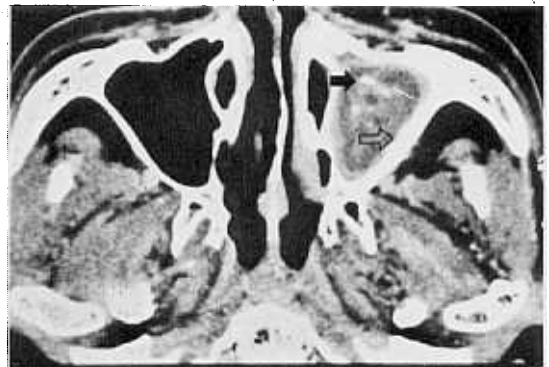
Axial CT scan showing calcification (→) and thickening of the sinus wall (⇨).
